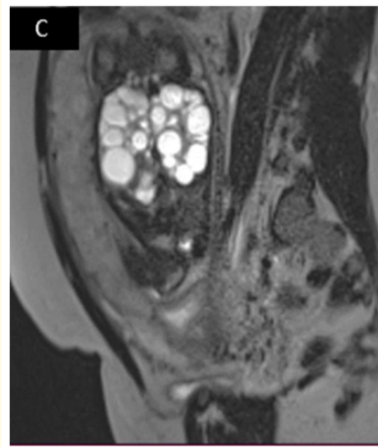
Fetal MRI in T2 sagittal (A) axial (B) and Coronal (C) sequences showing: renal parenchyma replaced by multiple thin-walled T2 hypersignal cystic formations, without septa or vegetations and absence of amniotic fluid.
